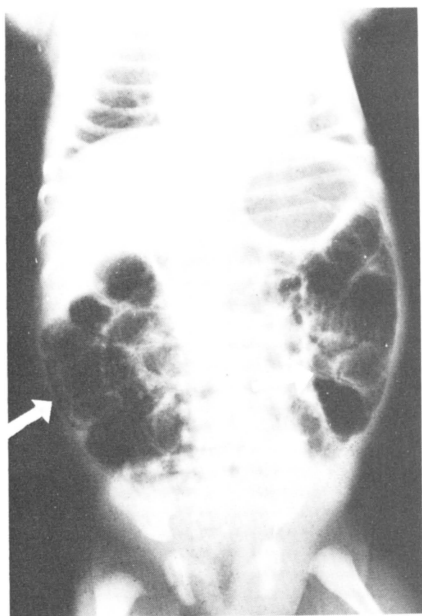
Abdominal radiograph demonstrating marked abdominal distention and the classical linear markings along the bowel surface characteristic of pneumatosis intestinalis (*arrows*).
